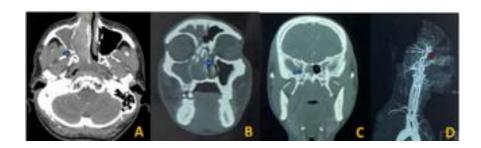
A. Axial slice of CT-Scan paranasal sinuses, there was a hyperdense lesion in the nasal cavity on the blue arrow and no erosion of the sphenopalatine foramen, B. Coronal slice, there was a hyperdense lesion in the frontal and maxillary sinus, C. Coronal slice there was a hyperdense lesion in the sphenoid sinus (blue arrow). D. Sagittal slice of CT-Scan angiography paranasal sinuses red arrow: right nasal cavity mass receiving blood supply from the right maxillary artery branch.
